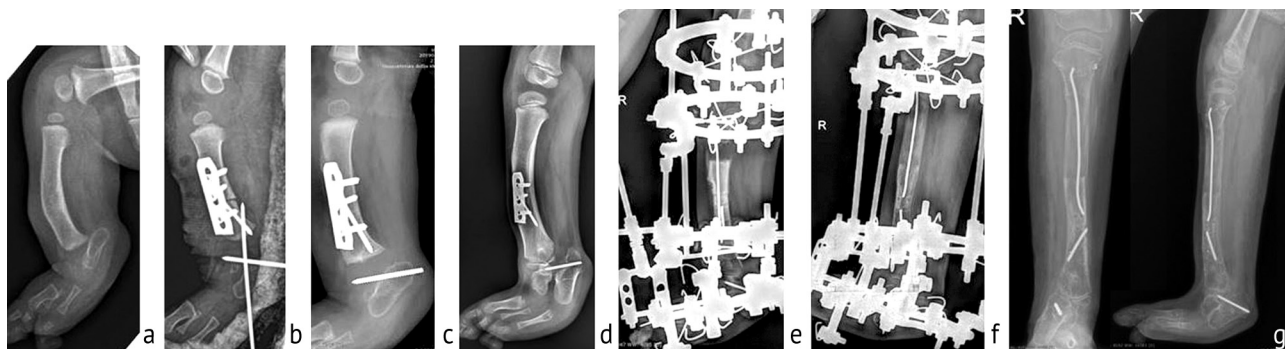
A case of developed foot equinus and its correction (X-rays): *a* before surgery; *b* first stage of deformity correction; *c* after removing the plaster cast; *d* equinus of the hindfoot 2 years after surgery; *e* second stage of treatment, lengthening with simultaneous gradual closed elimination of foot deformity using the Ilizarov apparatus; *f* before removing the Ilizarov frame; *g* after removing the frame, the foot remains in a satisfactory position, close to full weight bearing
